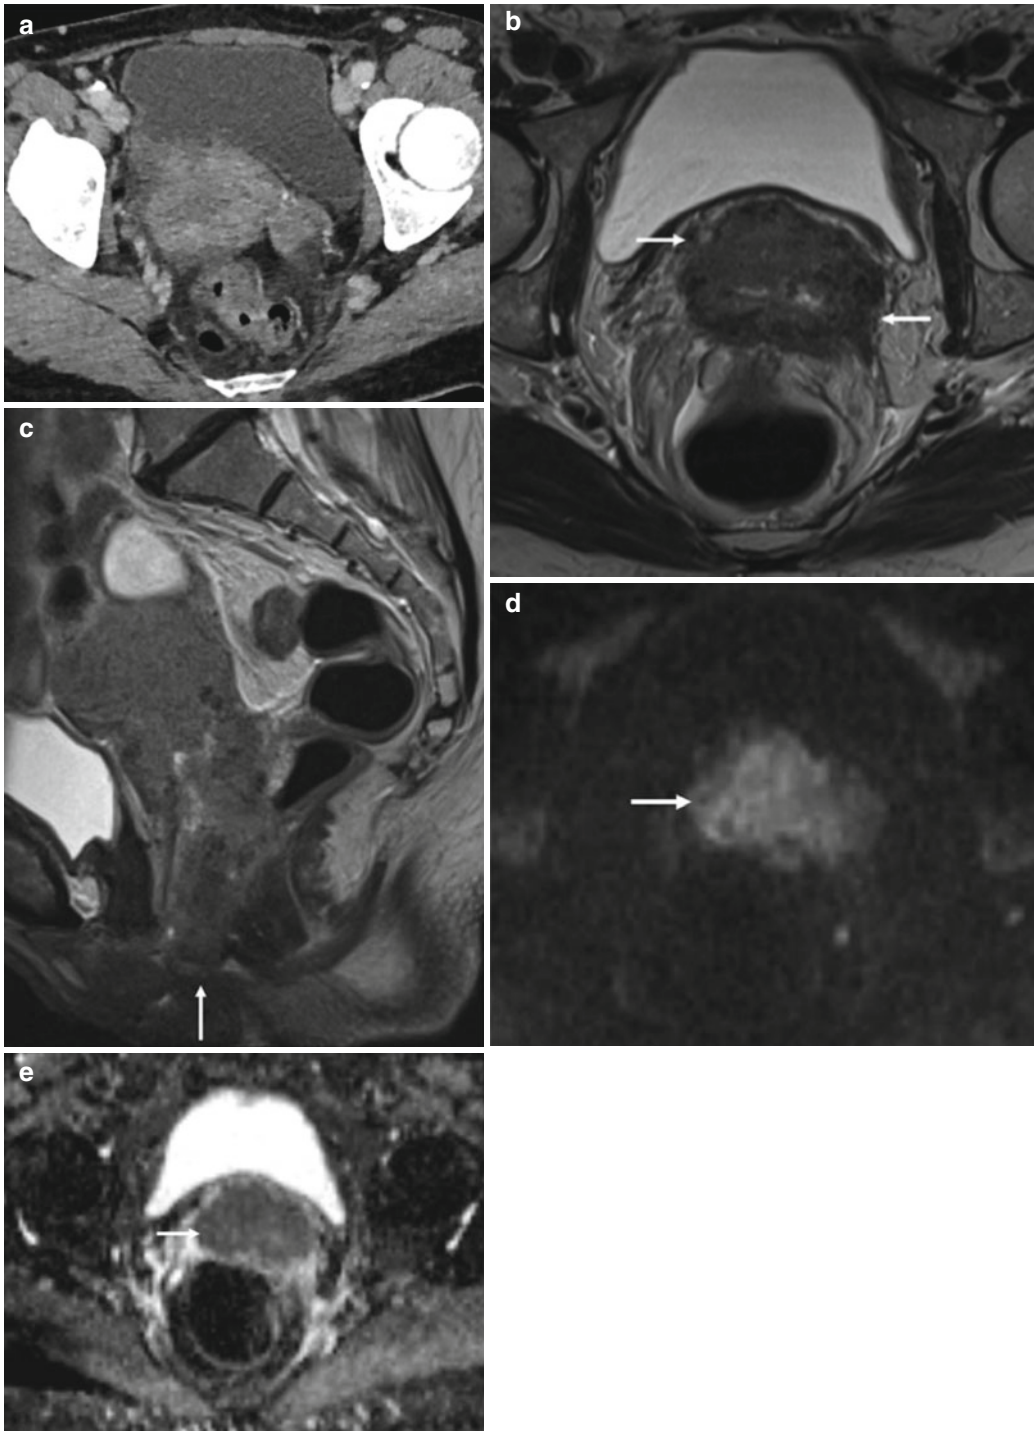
Squamous cell carcinoma of the cervix in a 70-year-old female: transverse CT (a), T2-weighted transverse (b), and sagittal (c) images demonstrate a bulky mass centered on the cervix and extending into both parametria (b, *arrows*) and inferiorly to the vaginal
